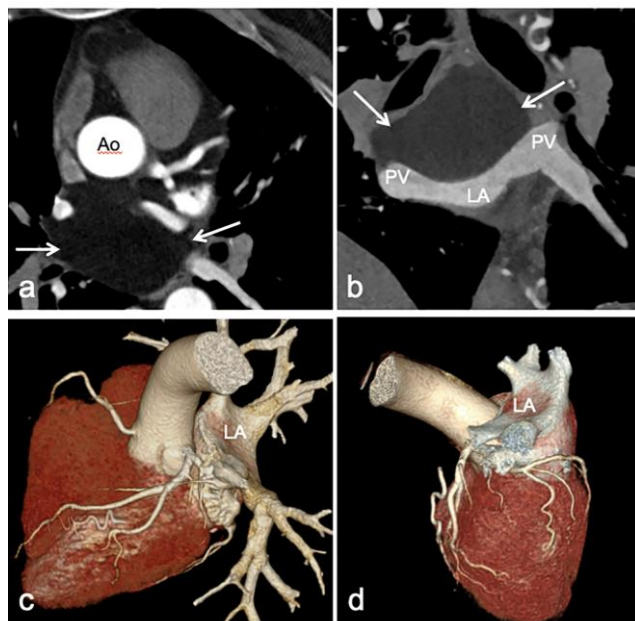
Coronary CT angiography. Axial (a) and coronal (b) images showing a well-circumscribed, homogeneous fat-attenuation mass consistent with lipoma. Coronal imaging (b) and 3-D volume-rendered reconstructions (c and d) demonstrate pronounced mass effect on the pulmonary veins and left atrium (Ao, aorta; PV, pulmonary veins; LA, left atrium).
